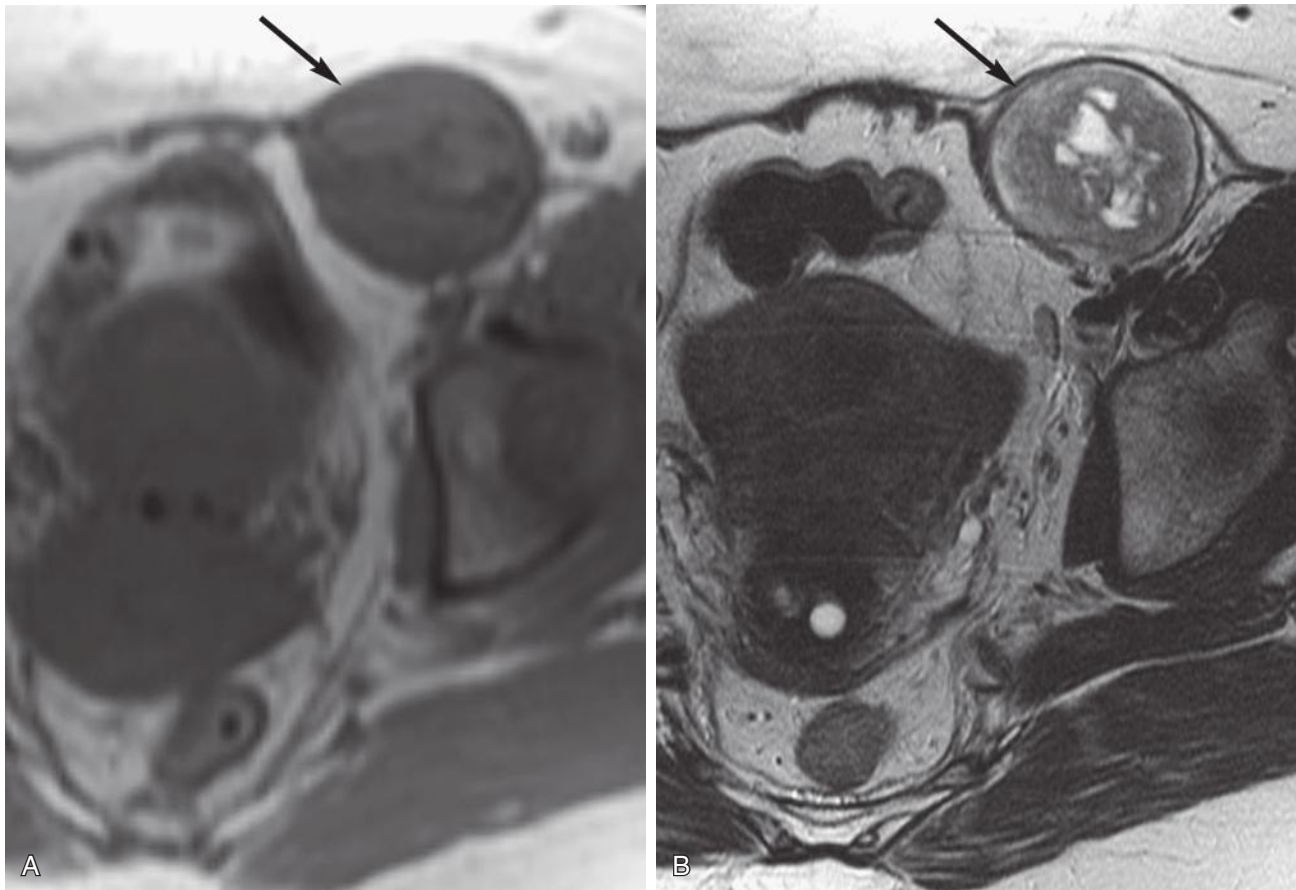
Round ligament leiomyoma. Axial T1-weighted (A) and T2-weighted (B) images demonstrate a round mass (arrows) with the typical appearance of a degenerating leiomyoma, predominantly low signal intensity on both sequences but with central irregular areas of high signal intensity on the T2-weighted image consistent with cystic degeneration. However, the mass is separate from the uterus and has herniated into the left inguinal canal. This mass was surgically proved to be a leiomyoma of the round ligament.
